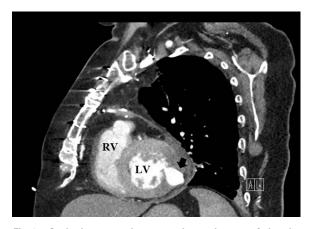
Sagittal computed tomography angiogram of the chest showing the LV pseudoaneurysm measuring 3.7×1.6 cm (black arrow, LV pseudoaneurysm). LV, left ventricle; RV, right ventricle.
